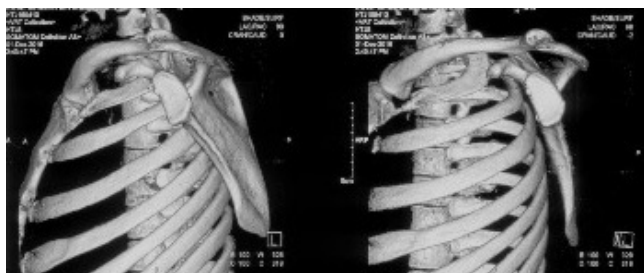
CT scan of the glenoid, pre-Latarjet
